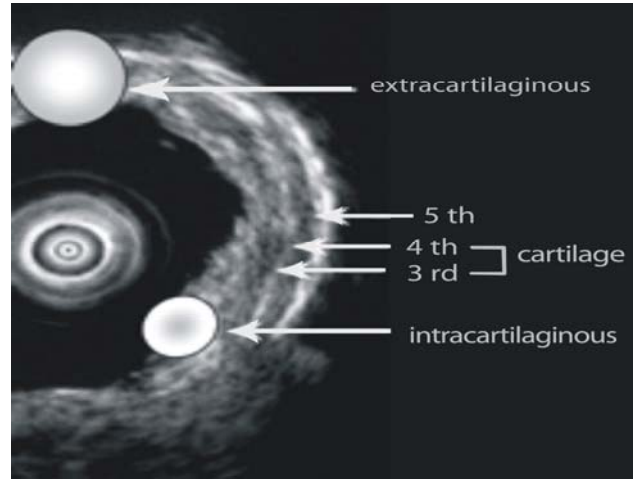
The classification of EBUS findings detected by bronchoscopist according to ultrasonographic image EBUS image showing a layered structure of tracheobronchial wall. Starting on the luminal side of the tracheobronchial wall, the third, fourth, and fifth layers (the hyper/hypo/hyperechoic layers) are induced by the presence of the cartilage. The depth of tumor invasion into the bronchial wall was determined by the cartilage layer and was divided into two categories: intracartilaginous (Class IIA) or extracartilaginous (classIIB).<sup>(20)</sup>
